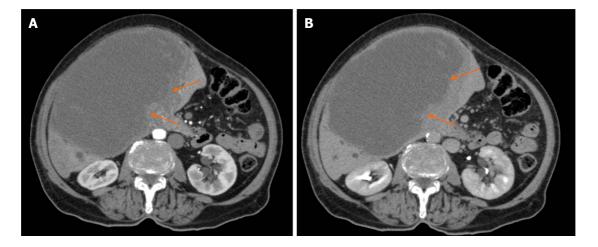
Abdominal computed tomography showing an expansive hepatic mass with a solid component (arrows). A: Intense arterial enhancement; B: Late-phase washout were present.
